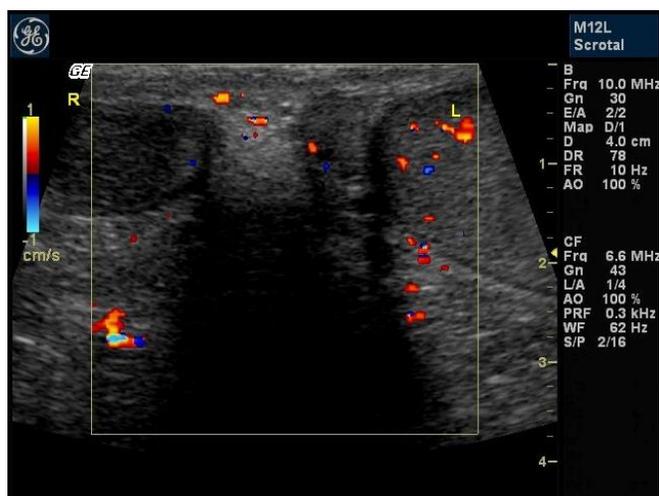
Color Doppler ultrasound (transverse plane, mid testes) in a case of chronic torsion displaying near absence of flow in the right testis. Notice the small scarred appearance of the right testicle. The patient reported severe right scrotal pain (suggestive of torsion) one year prior for which he did not seek medical care. His pain slowly resolved. No surgery was performed.
